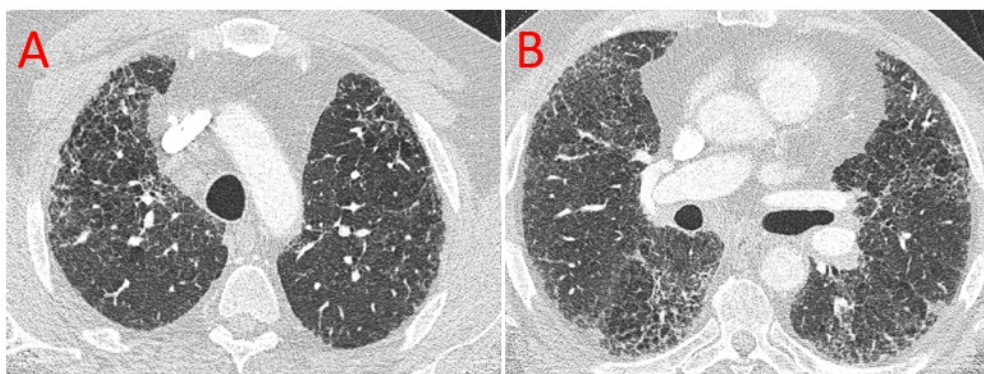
High resolution CT dicom's from a patient with Respiratory bronchiolitis interstitial lung disease from the ILD-PH cohort.
